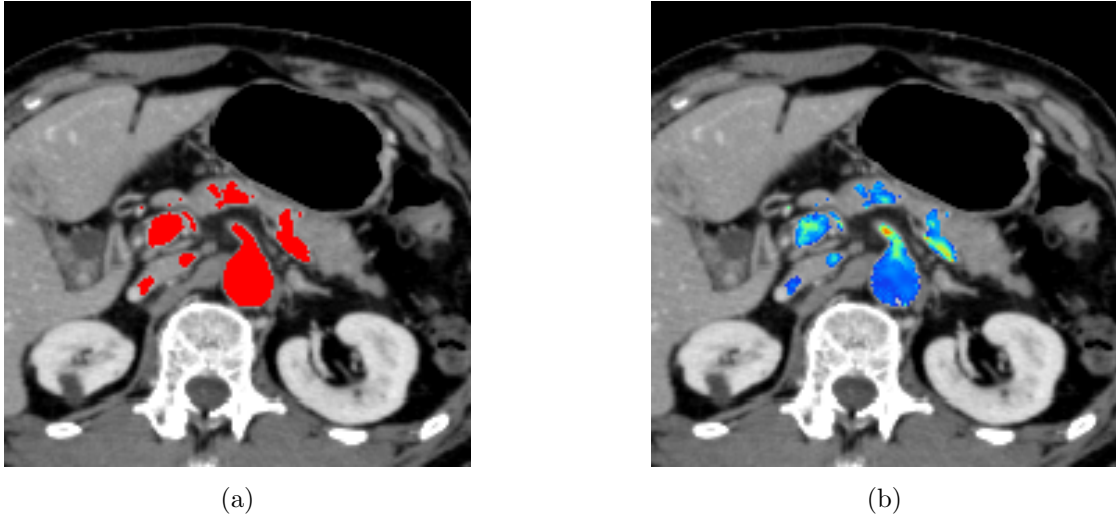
(a) Automatically extracted vessel structure binarized image overlapped with its CT slice. The vessel region is colored red. (b) Vessel structure enhanced image. Color code indicates a low enhancement with blue and high enhancement with red.
